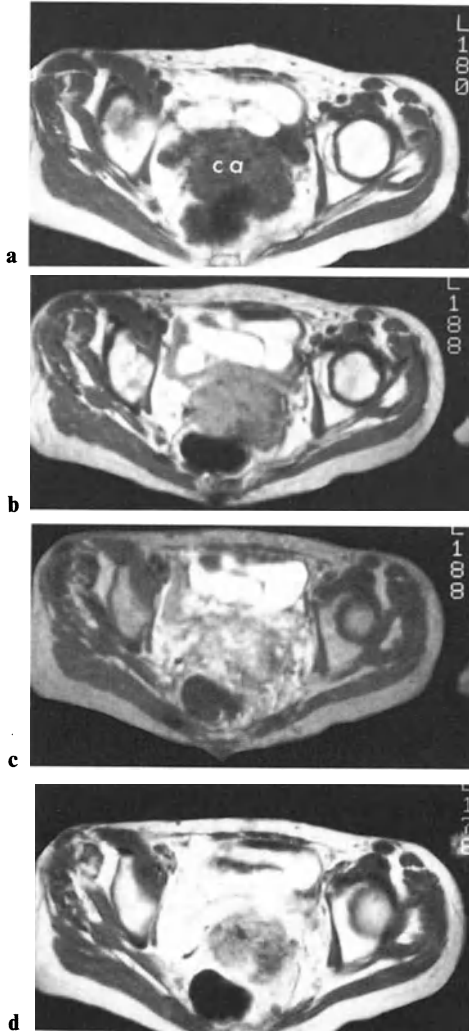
a–d. MRI: carcinoma of cervix stage IIb. a SE 500/20, b SE 2000/20, c SE 2000/80, d SE 500/20 after Gd-DTPA i.v. (0.1 mmol/kg/body weight). Note the irregular appearance of the carcinoma (*ca*), which is best visualized with T2 weighting and after administration of contrast medium
